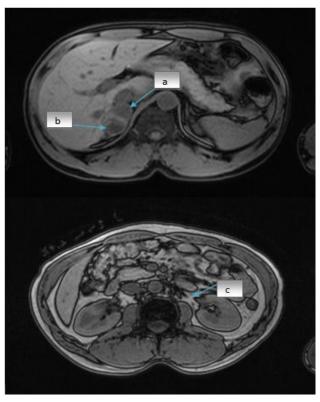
a: Magnetic resonance imaging (MRI) abdomen showing well encapsulated lesion 4.5x2.8x3.9cm in right supra renal location.
